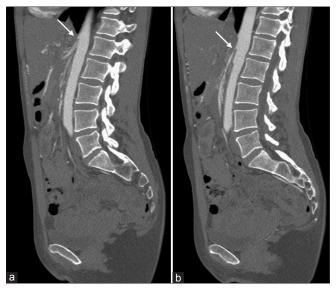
Computed tomography angiography (sagittal plane) showing high-grade stenosis (arrow) at the ostia of the celiac trunk (a) and superior mesenteric artery (b)
